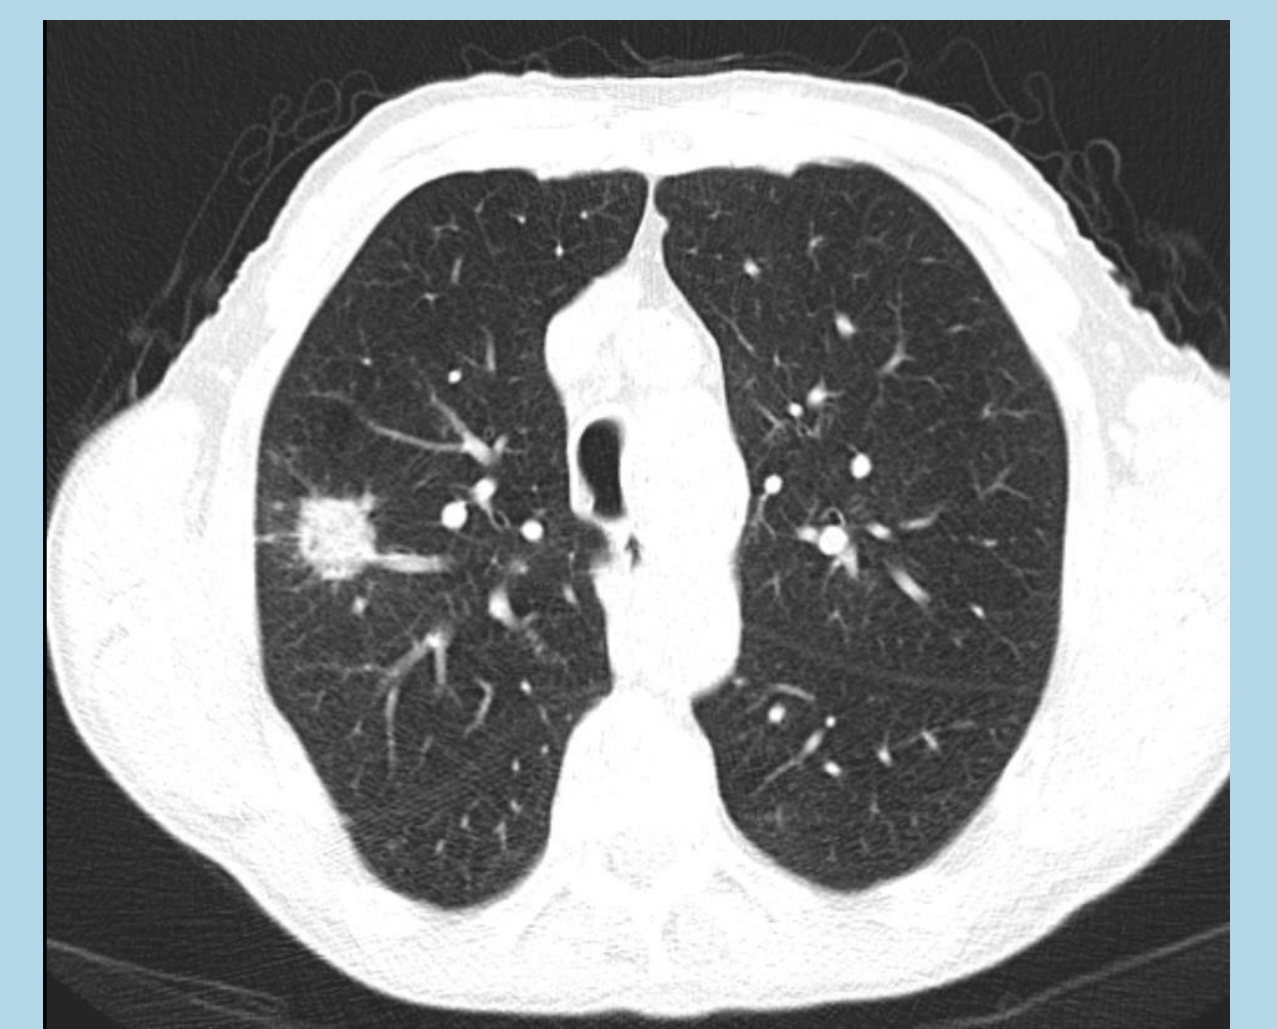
Example of CT image.
